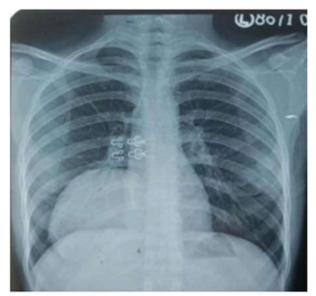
Chest X-ray showing lung hydatid cyst
